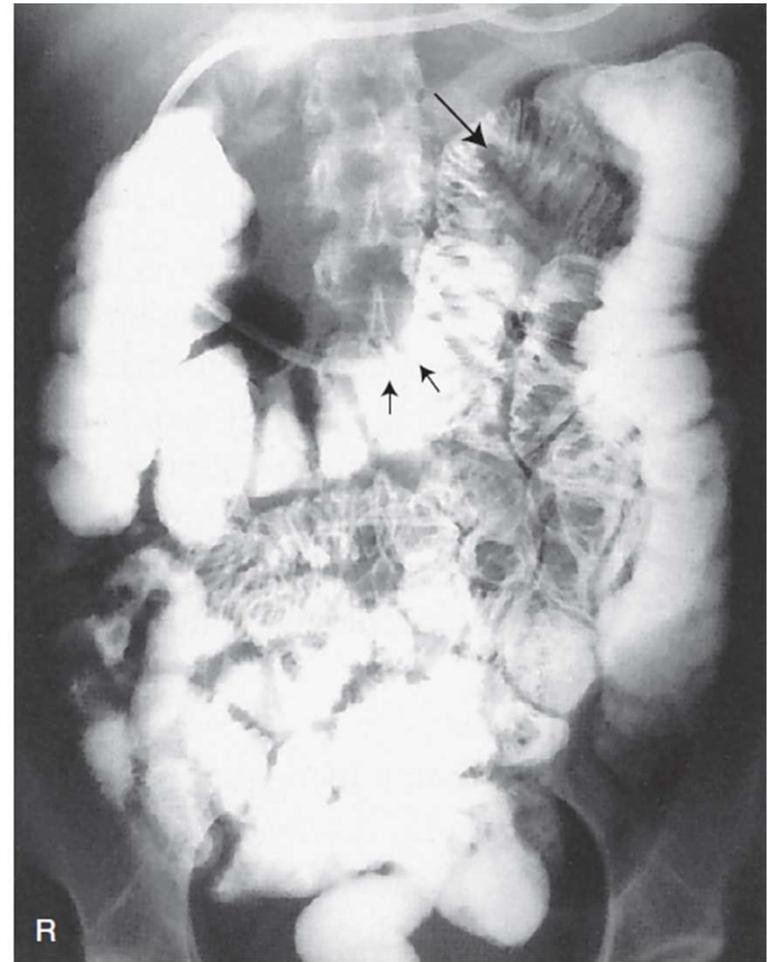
PA radiograph—enteroclysis.
